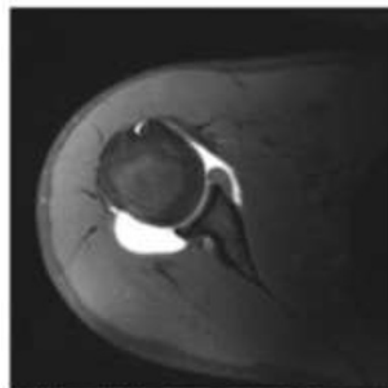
T1-weighted axial MR image acquired post gadolinium injection demonstrates good distention of the joint capsule. Diagnosis: MR Grade 3 tear with associated extensive anterior labral tear and SLAP complex, and tomolysis middle glenohumeral ligament.
